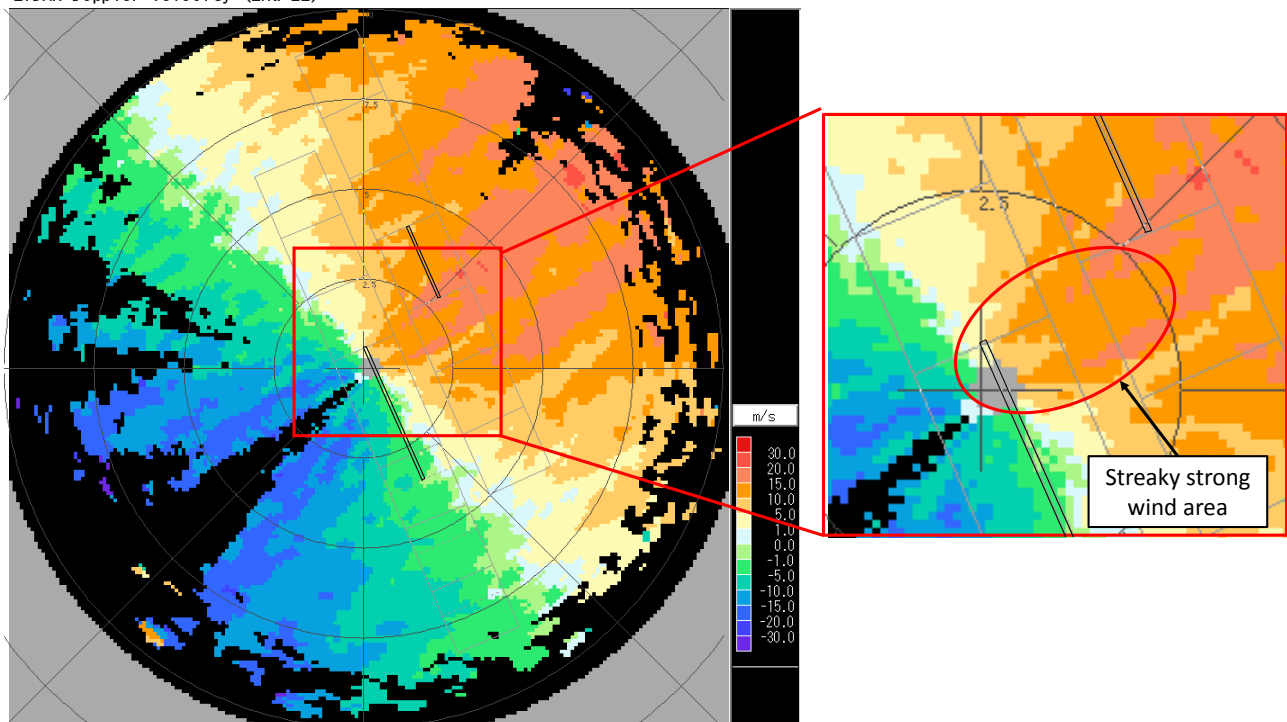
(1) Doppler velocity observation data (elevation angle 2°)
